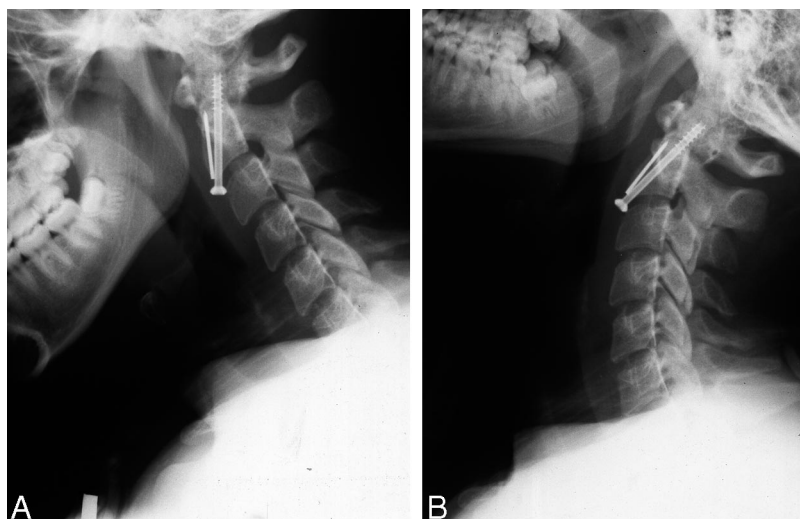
A and B, Flexion/extension C-spine radiographs obtained 24 months postoperatively.
